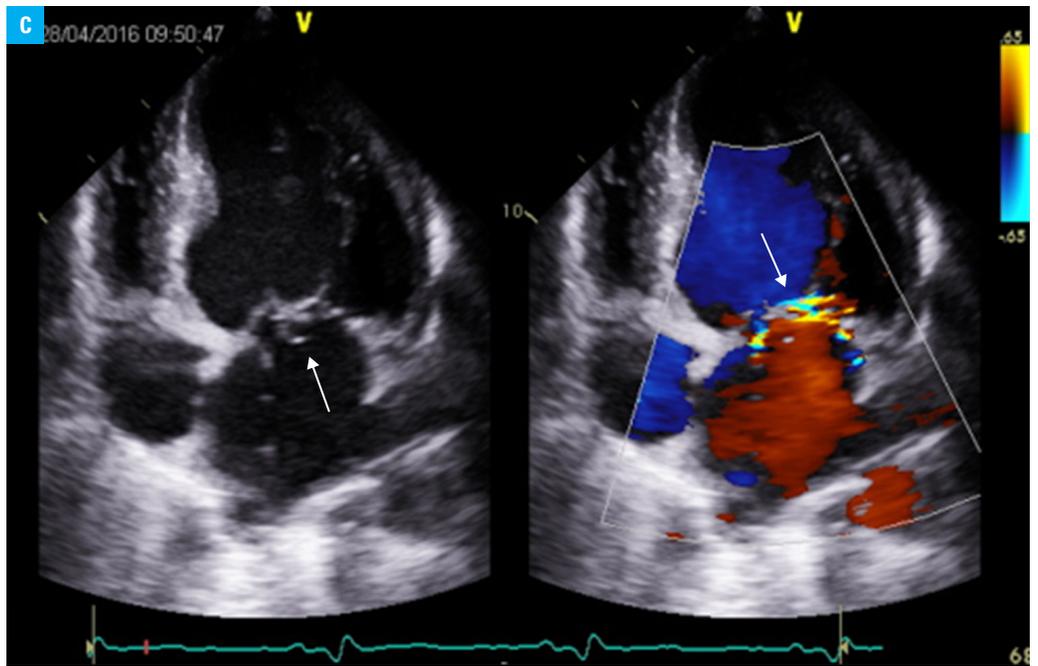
A – magnetic resonance image of the spine: inflammatory lesions of the intervertebral disc and L4/L5 vertebral bodies (arrow); B – transthoracic echocardiography: vegetations on right ventricular/high voltage (RV/HV) and atrial leads (arrows)
